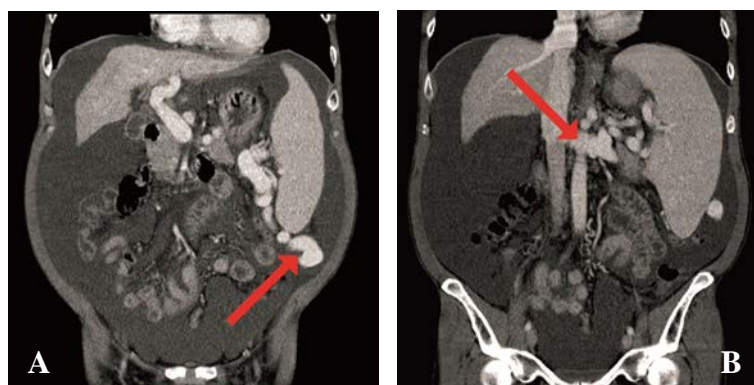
Preoperative computed tomography of patient No. 3. (A) The arrow indicates the portocaval shunt in the left iliac fossa. (B) The arrow indicates the splenorenal shunt
